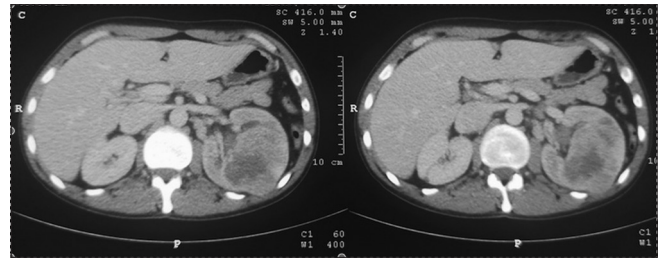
Computed tomography scan showing a mass of the left kidney and hyperdense elements in the kidney pelvis probably due to clots
